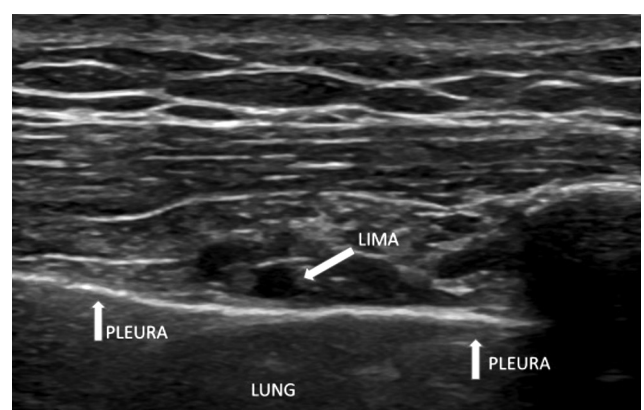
Ultrasongraphic view of the left internal mammary artery.
